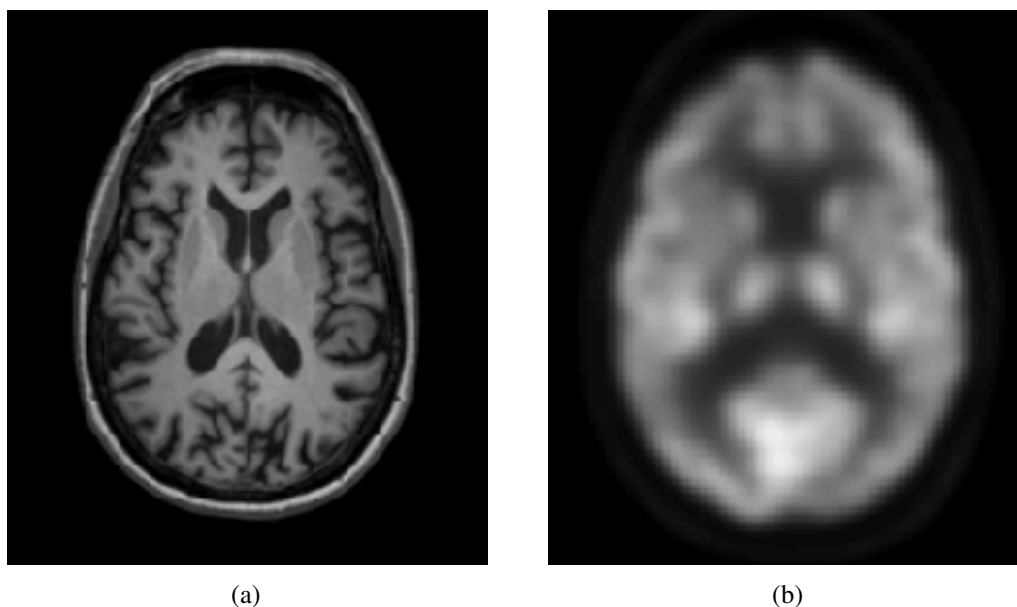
Difference in structural and functional imaging of an Alzheimer’s disease patient from ADNI database. (a) MR image using magnetization-prepared rapid gradient-echo (MP-RAGE) (b) Fludeoxyglucose (FDG) PET.
